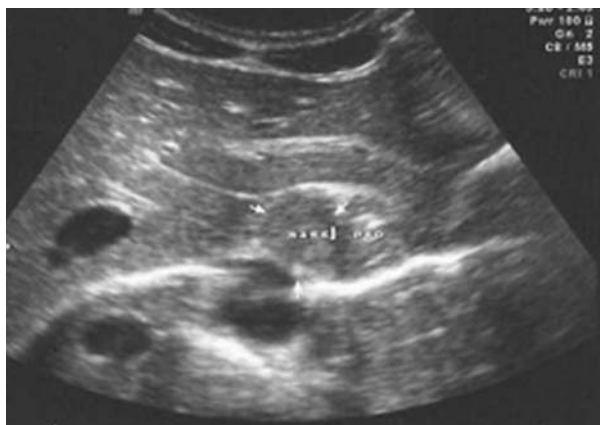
Sonographic finding showing a hypoechoic mass adjacent to abdominal esophagus.
